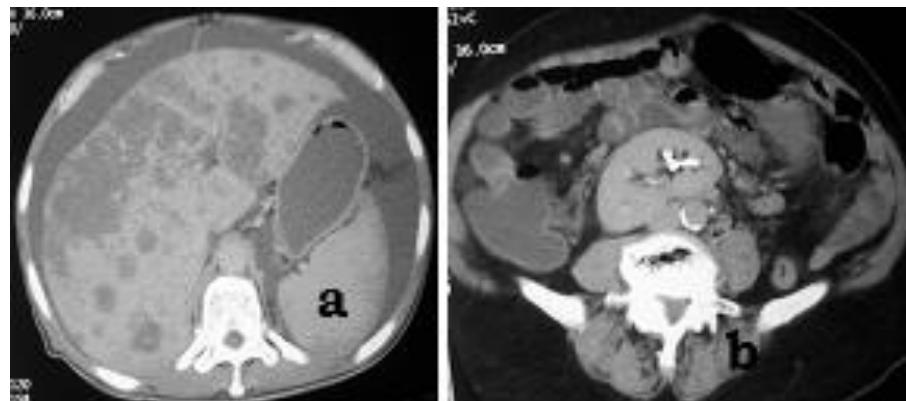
CT images in acute abdomen showing, a. Liver metastasis with ascites. b. Renal calculus in a midline ectopic kidney in another patient.
